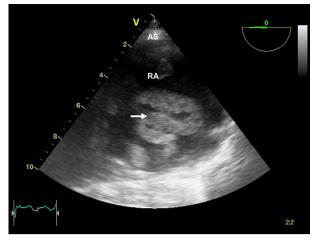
Transesophageal echocardiography confirming the free-floating, worm-like, homogeneous thrombus $(3 \times 7 \text{ cm}, \text{ arrow})$ in the right atrium, originating from the inferior vena cava. RA = right atrium, AS = atrial septum.
